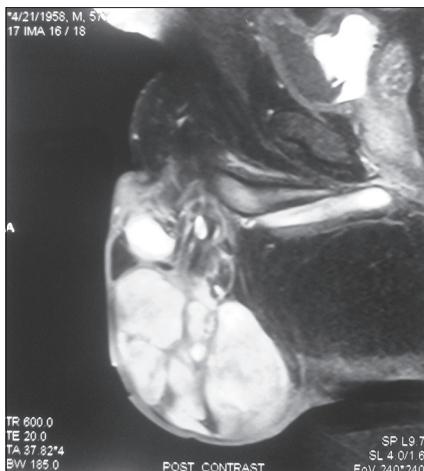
Magnetic resonance imaging scrotum—multiple, well-defined, and homogenously enhancing extra testicular masses with fat component
